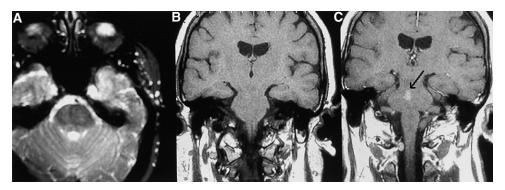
Telangiectasis. (A) T2-weighted image of the midbrain. (B) T1-weighted image did not reveal any abnormalities. (C) Contrast-enhanced T1-weighted image demonstrates an enhancing lesion in the midbrain (*arrow*).
